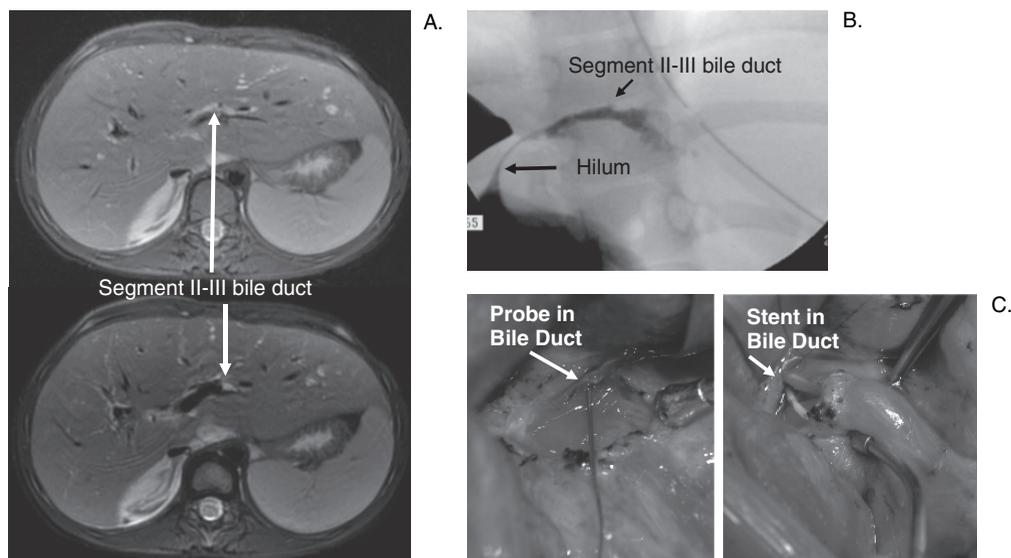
Dilated segment II/III bile ducts in patient with recurrent cholangitis, 5 years following a successful Kasai portoenterostomy. (A) MRI scan with dilated bile duct; (B) operative cholangiogram showing dilated Segment II/III bile duct; (C) postdilation and stent placement within the intrahepatic bile duct remnant.
